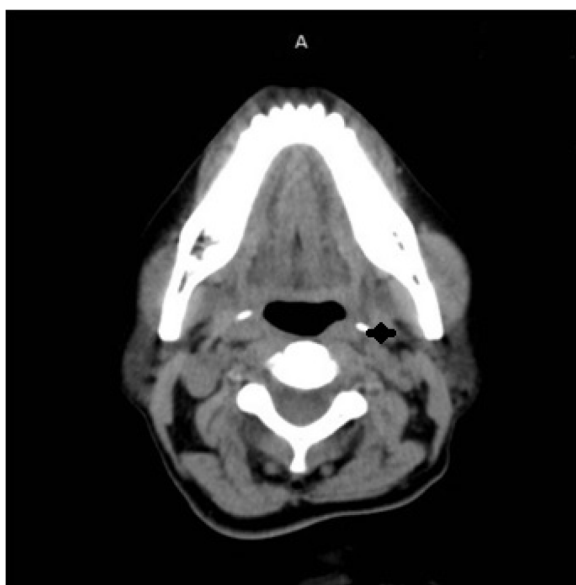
CT (axial) showing bilateral styloid process (black arrow marking the left styloid bone)
